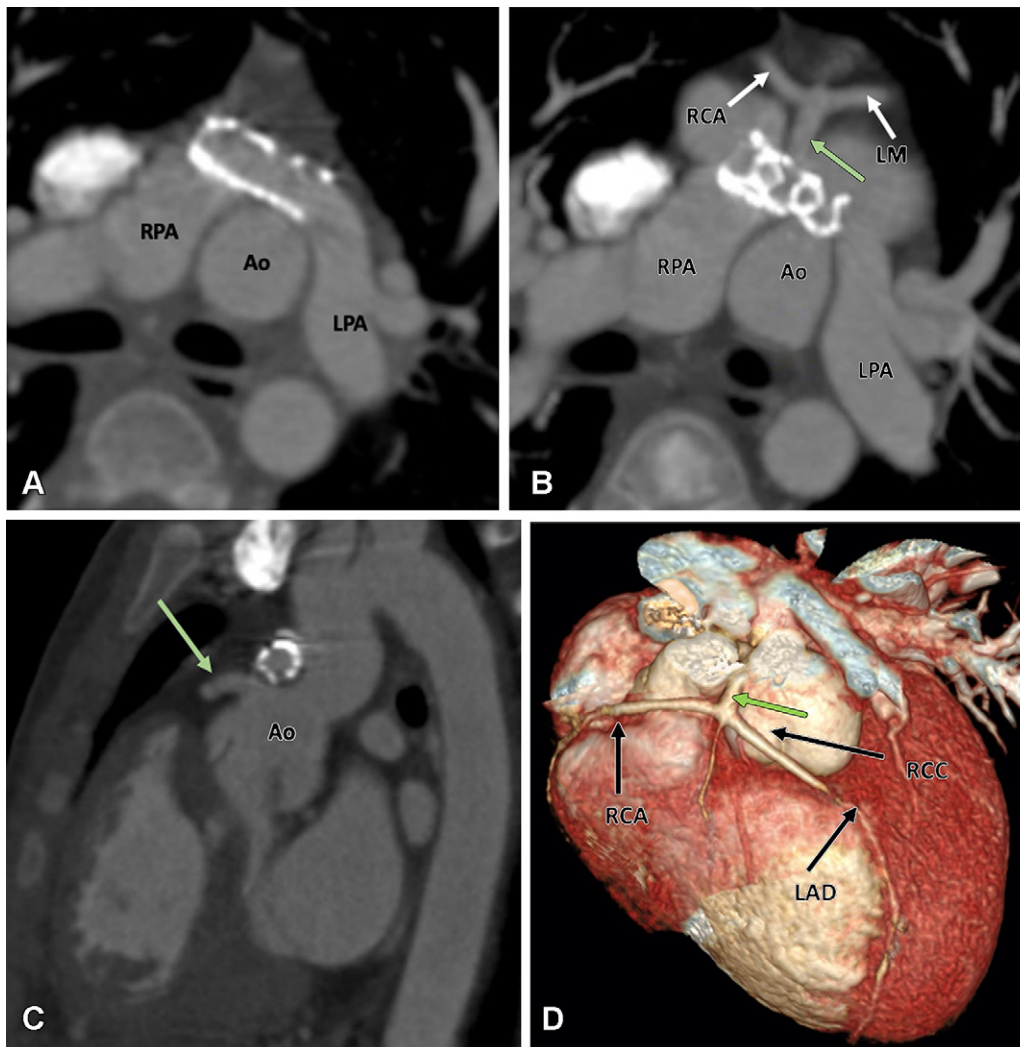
Postoperative appearance after an arterial switch procedure and LPA stent placement for treatment of dextrotransposition of the great arteries in a 14-year-old boy. (A) Axial maximum intensity projection (MIP) CT image shows the location of the main pulmonary artery anterior to the aorta. The patent stent is seen in the proximal LPA. The origin of the RPA is jailed. Stent placement was done to relieve recurrent LPA stenosis. (B) Axial and (C) sagittal MIP CT images show a single coronary artery (green arrow). A single common trunk arises from the aorta, which divides into the RCA and LM (white arrows in B). The LPA with stent is abutting the single coronary artery at its origin, but no evidence of ostial stenosis is seen. The aortic root appears dilated. (D) Volume-rendered image confirms the single coronary artery arising from right coronary sinus. Ao = aorta, LAD = left anterior descending artery, LM = left main trunk, LPA = left pulmonary artery, RCA = right coronary artery, RCC = right coronary sinus, RPA = right pulmonary artery.
